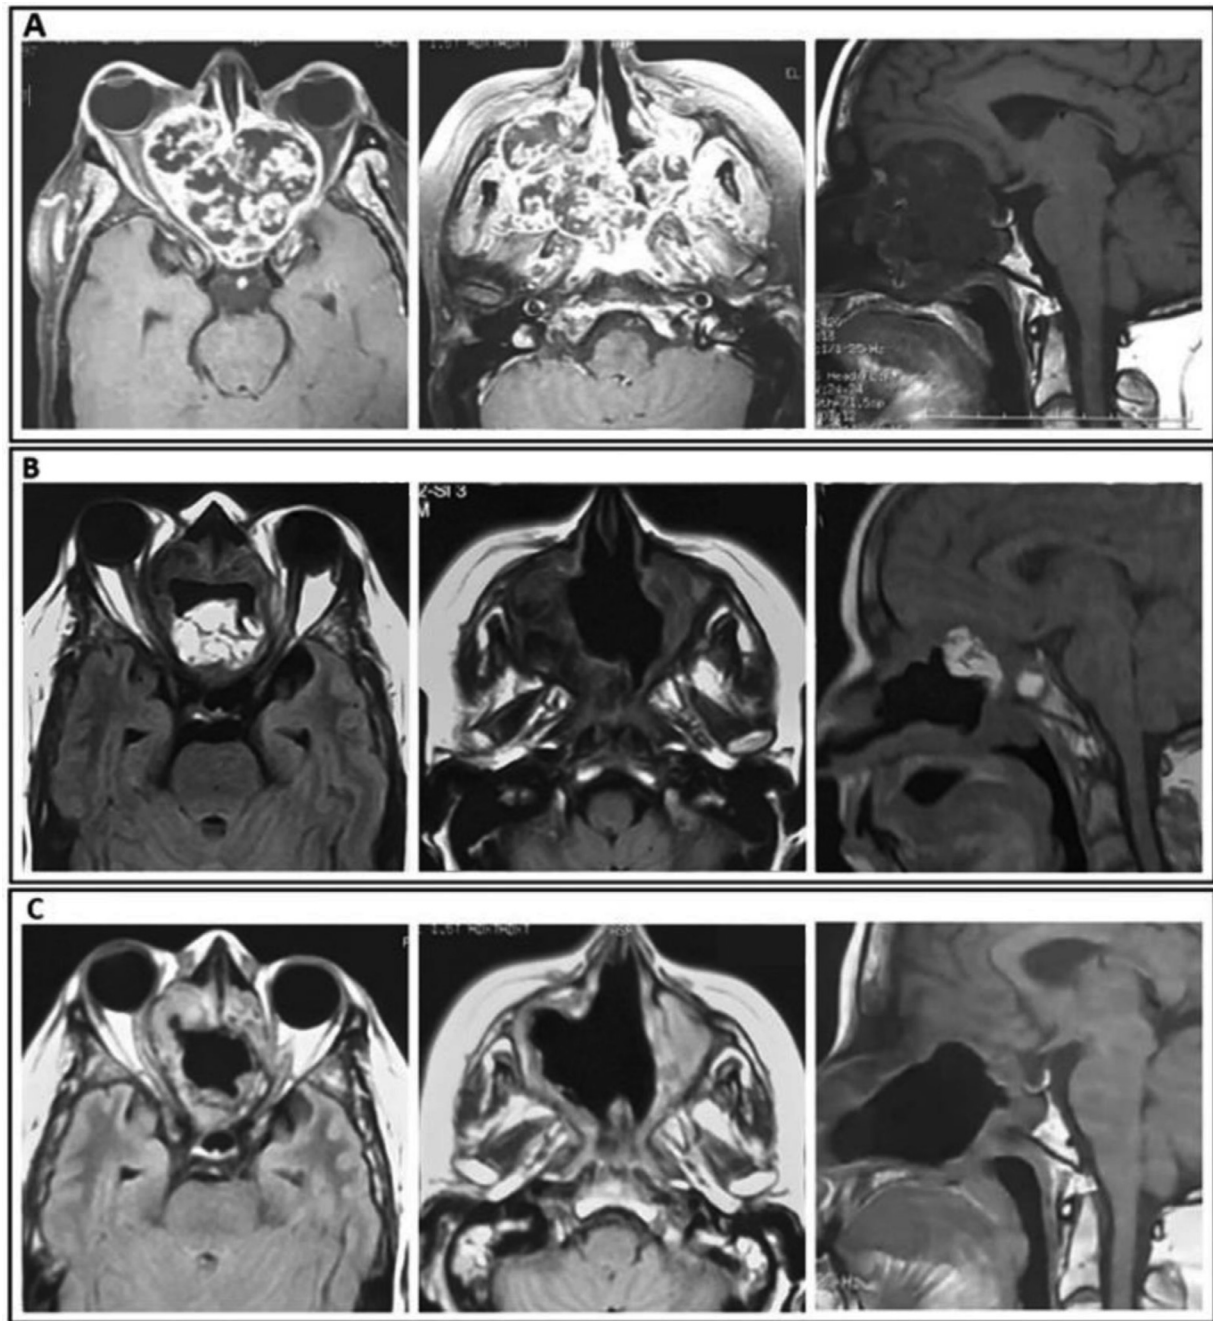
Axial and sagittal T2-weighted MRI showing the tumor extension: (A) before any treatment; (B) 3 weeks after surgery and before RT; (C) 8 months after RT
